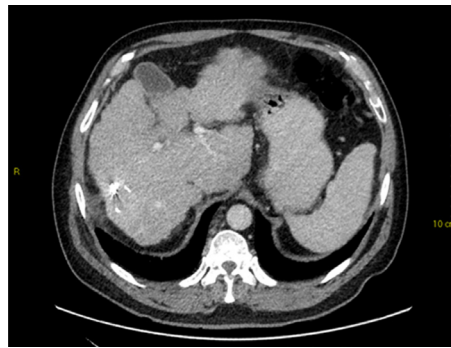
Contrast-enhanced computed tomography at 1 year after stereotactic body radiotherapy showing volume loss with capsular retraction (note fiduciary clips *in-situ*)
